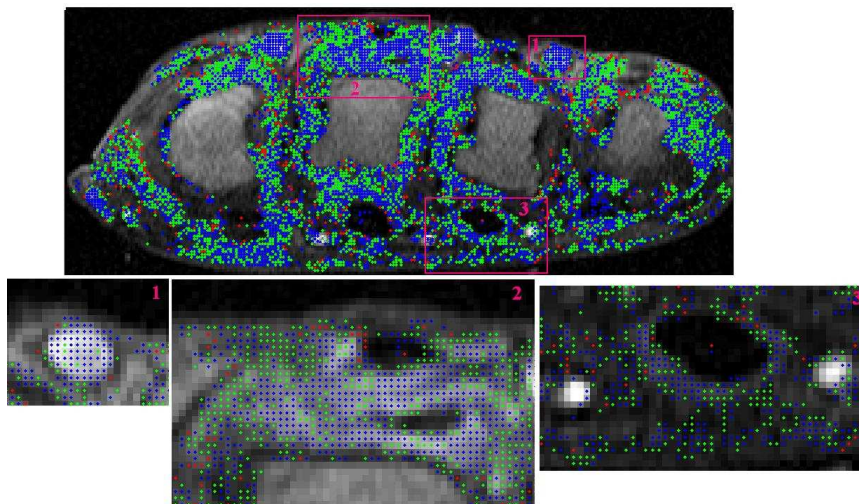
Resulting map of the contrast agent uptake obtained for a sample DCE-MRI temporal slice of the MCP joints acquired with the high field scanner. The colours in the image correspond to the models each normalised signal intensity vs. time curve assumed:  $M_1$  -red,  $M_2$ -green, and  $M_3$  -blue. Below are three magnified regions: (1) blood vessel, (2) inflamed tissue, and (3) skin region.
